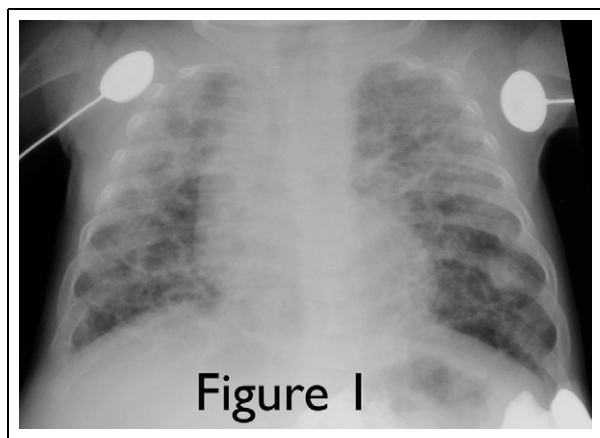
Chest radiograph of an infant with old bronchopulmonary dysplasia. The infant is intubated and the lungs appear cystic and scarred with areas of hyperinflation and atelectasis.
